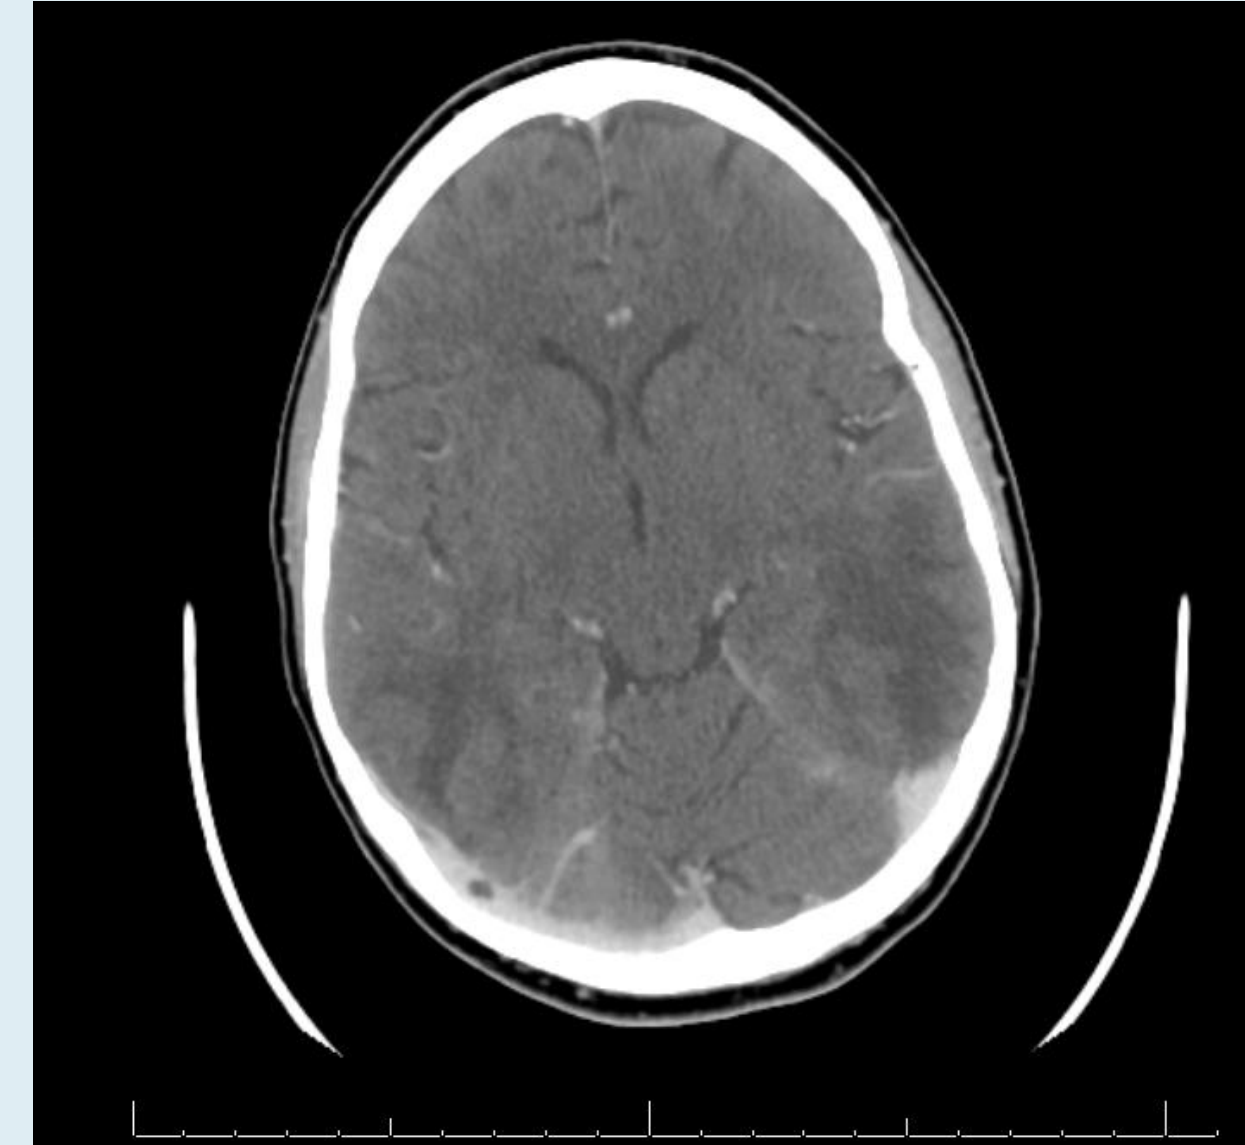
CT head with contrast showing PRES
